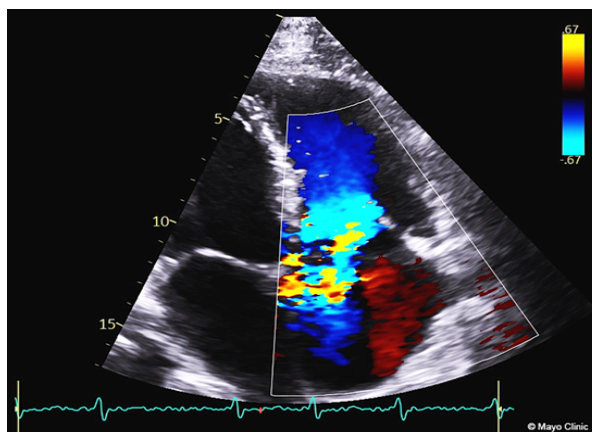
Colour Doppler from the transthoracic echocardiogram (4-chamber view) during ventricular systole reveals a very wide jet of severe tricuspid regurgitation with the backward flow of blood from the right ventricle to the right atrium.
